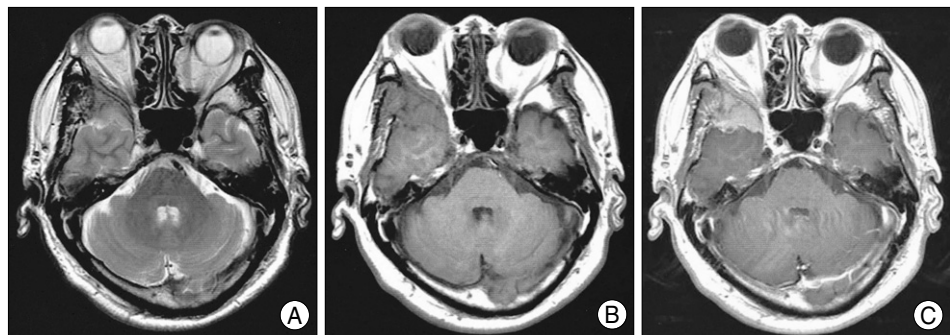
Axial T2-weighted (A) and T1-weighted (B) images show an extraaxial mass in the right sphenoid ridge area. This mass extends lateral wall of right orbit and medial aspect of right temporalis muscle. After contrast (C), strong enhancement is seen.
